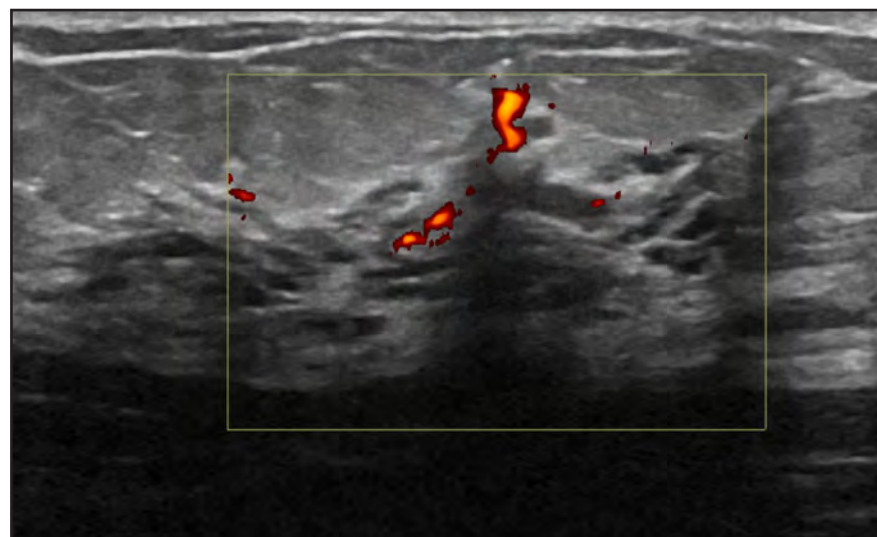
Power Doppler imaging in the sagittal plane
